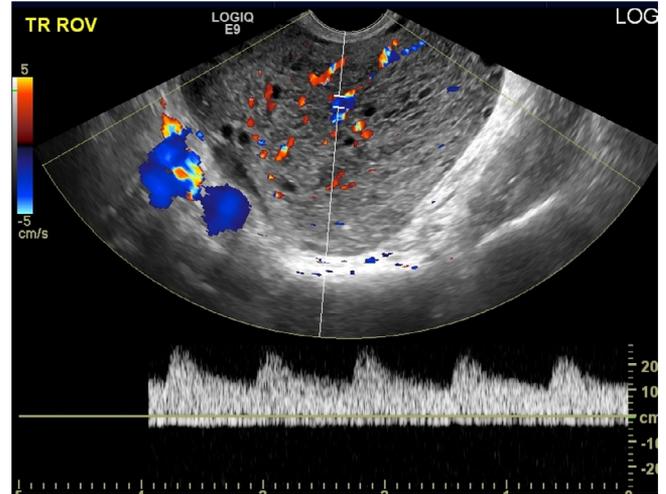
Predominantly solid ovarian mass with moderate vascular flow noted consistent with a color Doppler score of 3. Surgical diagnosis was an enlarged torsed polycystic ovary without a tumor.
